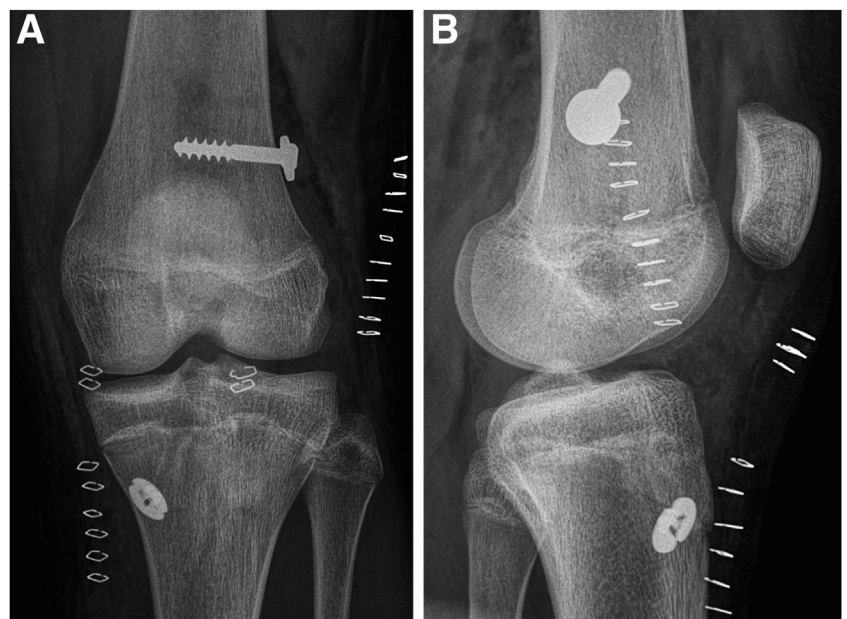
Final anteroposterior (A) and lateral (B) x-ray views.
